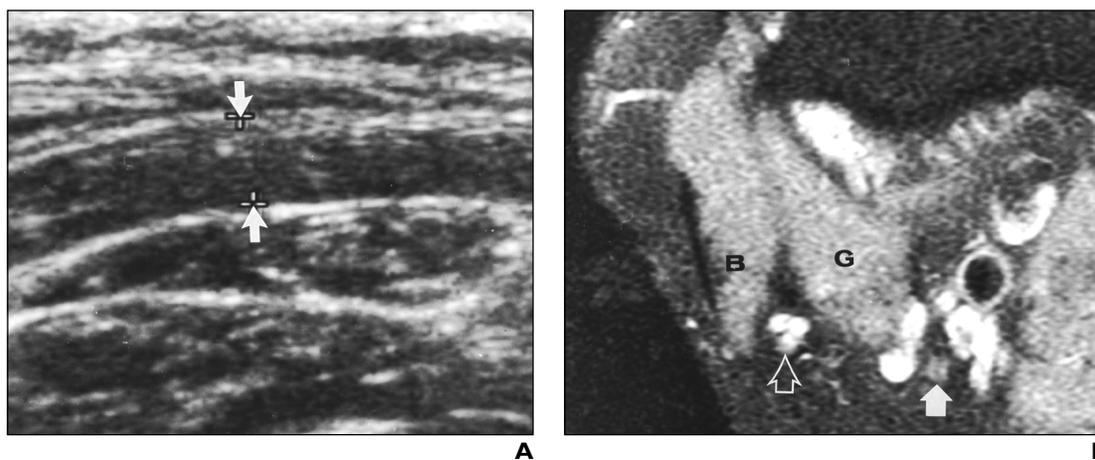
34-year-old man with intraneural perineuroma diagnosed after surgical biopsy. A, Longitudinal 5-12-MHz sonogram shows fusiform hypoechoic swelling of right common peroneal nerve (*arrows*). B, Axial STIR MRI shows intraneural perineuroma of common peroneal nerve at level of proximal popliteal fossa, with enlarged hyperintense fasciculi (*open arrow*) between biceps femoris muscle (B) and lateral head of gastrocnemius muscle (G). Compare with healthy tibial nerve (*solid arrow*) between veins.
